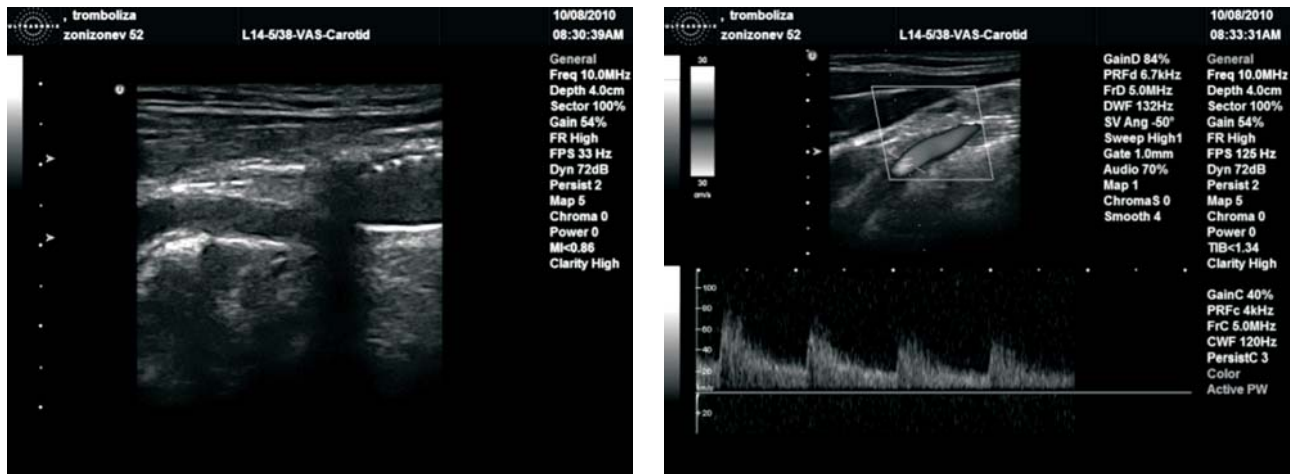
Control Doppler sonography of left carotid artery after stent
